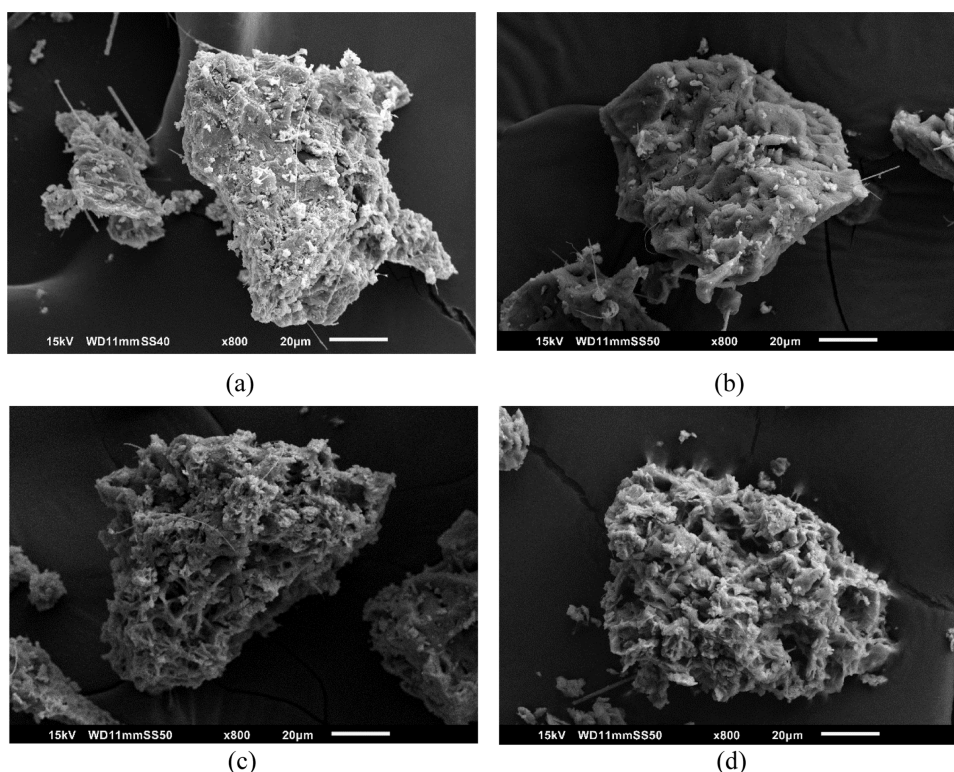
SEM images of particles from ultrasound-induced crystallization and seeds-induced crystallization. Flow rates of AA/HCl/seeds (mL/min)—sonication condition: (a) 6/0.42/0 – 8 W, (b) 6/0.42/1.0 – silent, (c) 12/0.84/0 – 8 W, and (d) 12/0.84/1.0 – silent.
